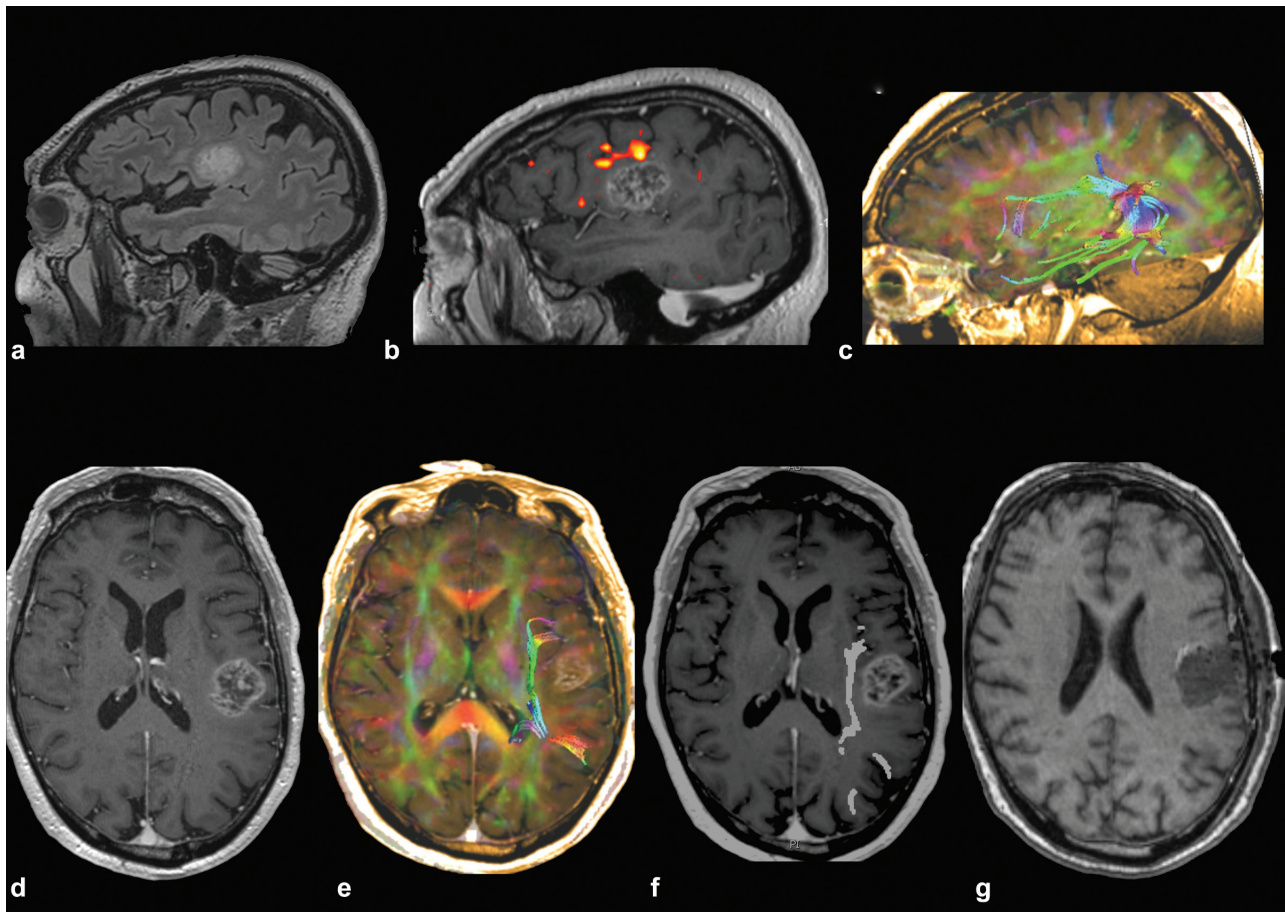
Preoperative diffusion tensor imaging (DTI) tractography of the arcuate fasciculus (AF) to inform planning of awake craniotomy with speech and motor mapping and monitoring in a 72-year-old right-handed man diagnosed with glioblastoma. (a, d) Preoperative sagittal and axial contrast-enhanced magnetic resonance imaging (MRI) demonstrating enhancing lesion in the dominant subcentral gyrus extending into the posterior insular. (b) Silent word generation language functional MRI shows left-side language dominance. The activated anterior language areas are seen in the inferior and middle frontal gyri, in close proximity to the anterior and superior border of the lesion. (c, e) Left AF three-dimensional reconstruction to demonstrate relation of the tract to the lesion. (f) Intraoperative neuronavigation MRI with DTI tractography of the AF. (g) Postoperative contrast-enhanced MRI demonstrates > 95% extent of resection. Postoperatively there was a transient subtle deterioration in expressive dysphasia that improved to the patient's baseline by postoperative day 10.
